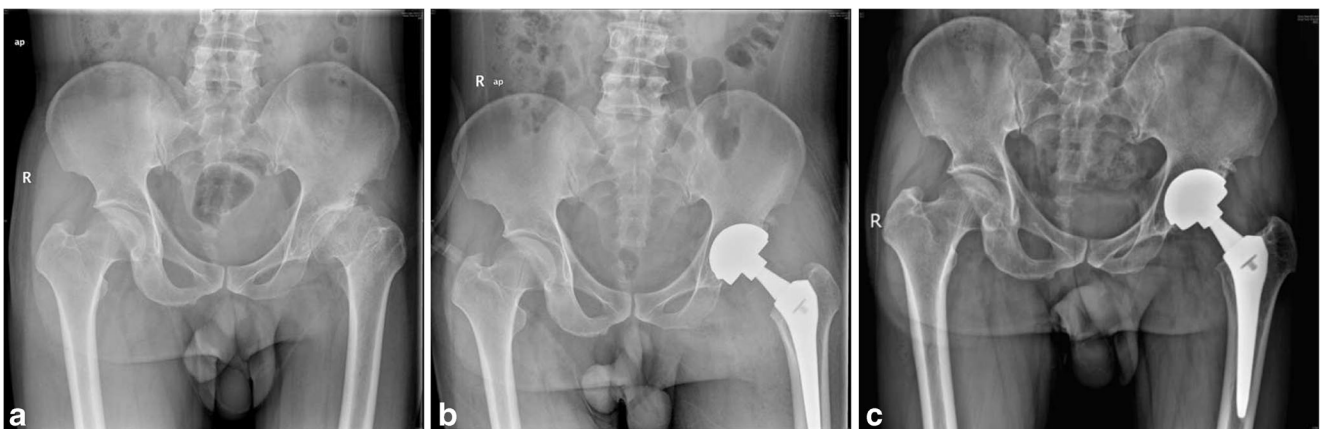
A 46-year-old farmer sustained left hip osteoarthritis secondary to DDH. LDH MoM THA was performed in 2008. Pelvic radiographs: a preoperation, b 5 days post operation, c 8.5 years post operation
